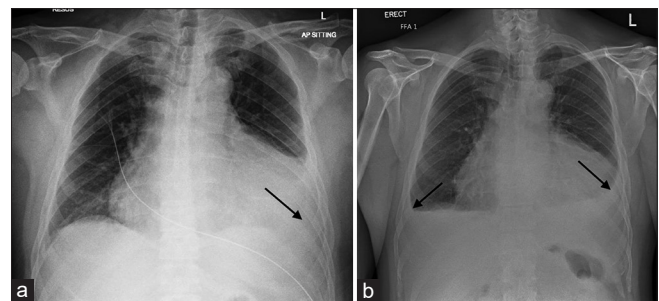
(a) Chest radiograph taken on first presentation to the emergency department (ED) (Day 7 postvaccination) shows a small left pleural effusion (arrow). (b) Chest radiograph taken on second presentation to ED (Day 12 postvaccination) shows worsening pleural effusions bilaterally (arrows).
